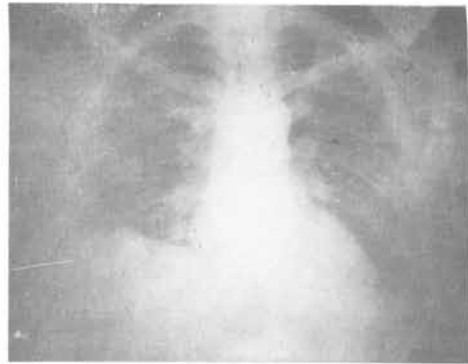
X-ray chest after chemotherapy showing clearance of metastases.
